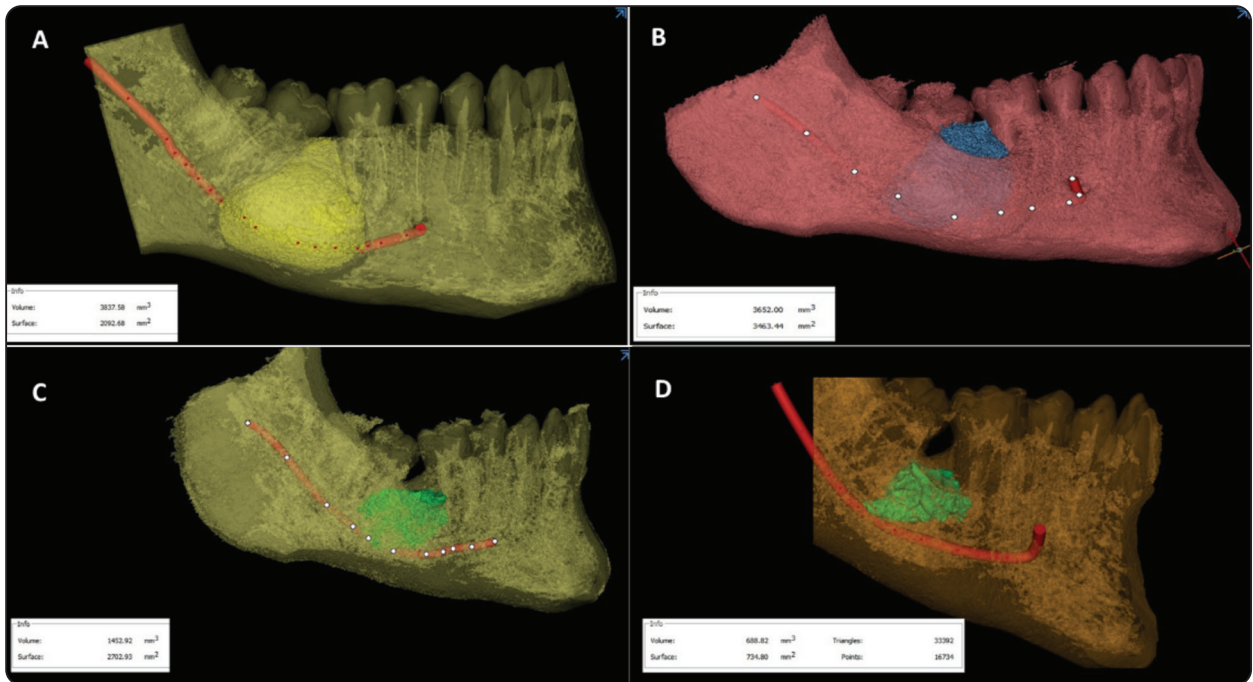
CBCT images showing marked decrease in cystic volume during follow up periods: A) preoperative. B) 3months postoperative. C) 6 month postoperative. D) 9 month postoperative.
